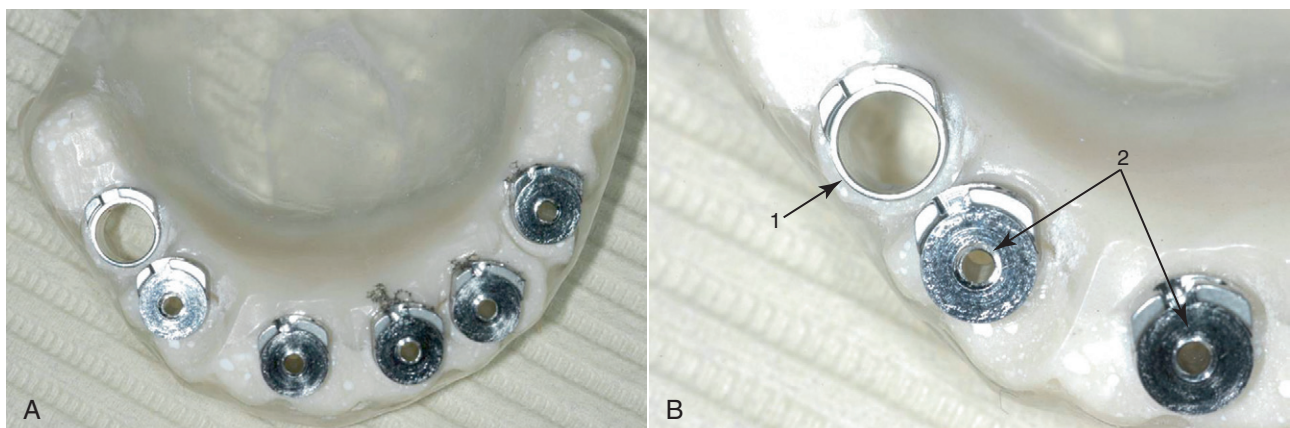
A and B, Surgical guide produced from the treatment plan using VIP Treatment Planning Software (Biohorizons, Inc., Birmingham, Alabama) and a computed tomography scan. (1) Sleeve removed to allow for appropriate countersink of bur as determined by abutment height; (2) Guide for 1.6 bur.
